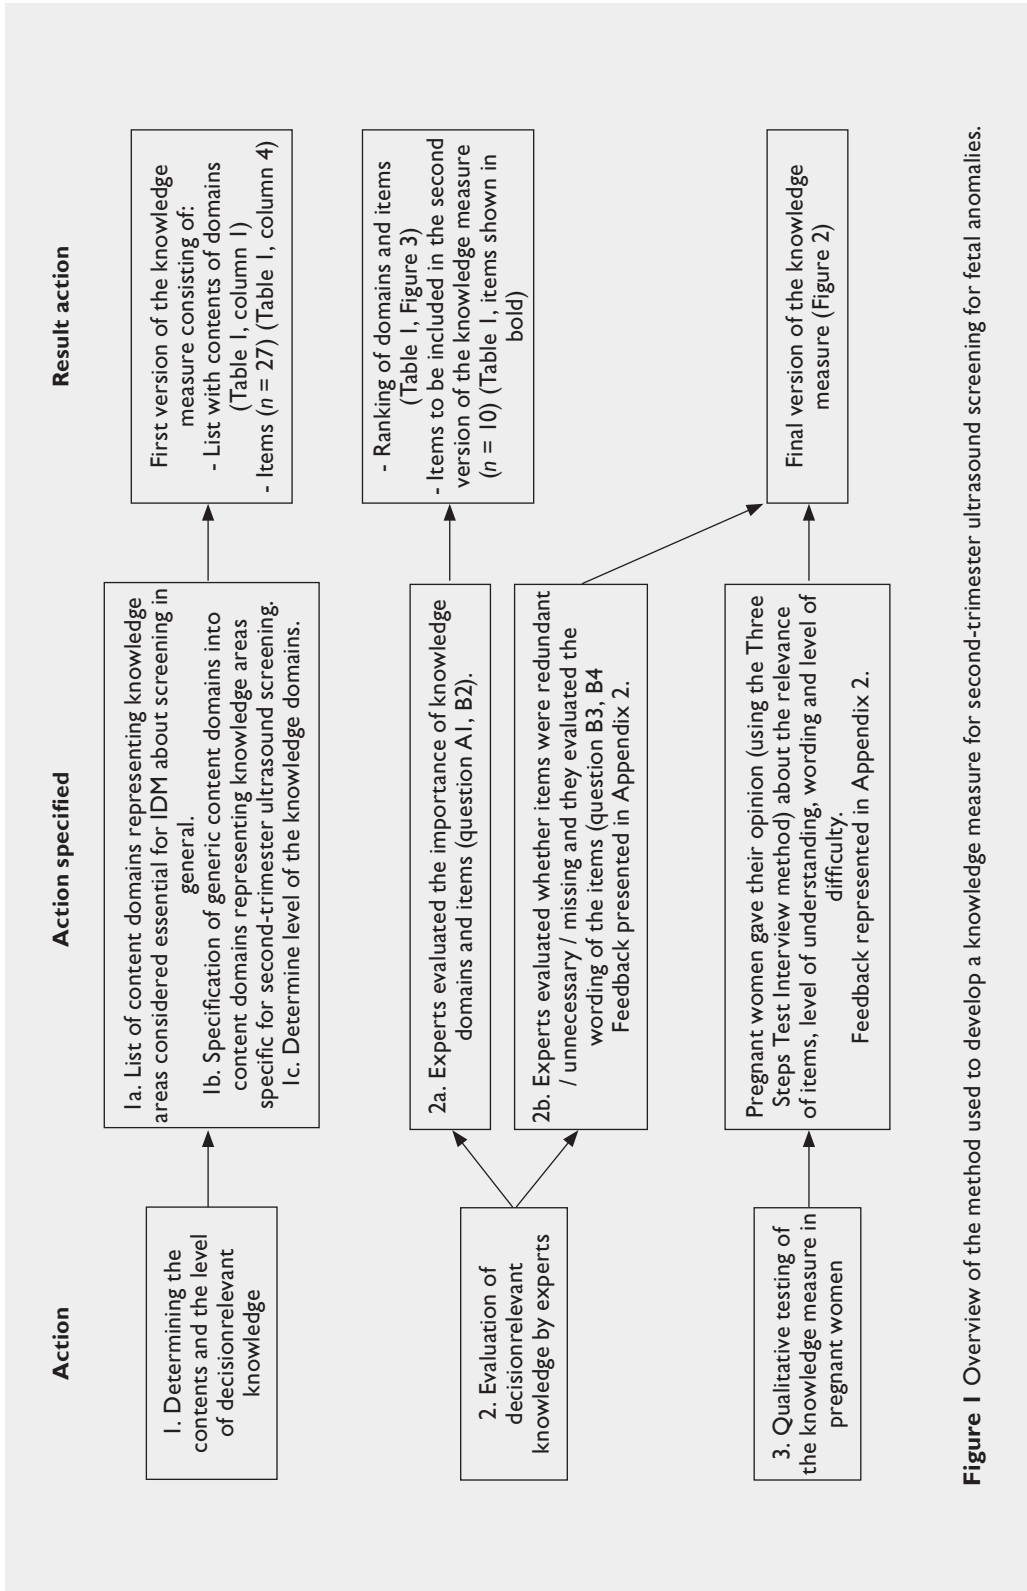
Overview of the method used to develop a knowledge measure for second-trimester ultrasound screening for fetal anomalies.
